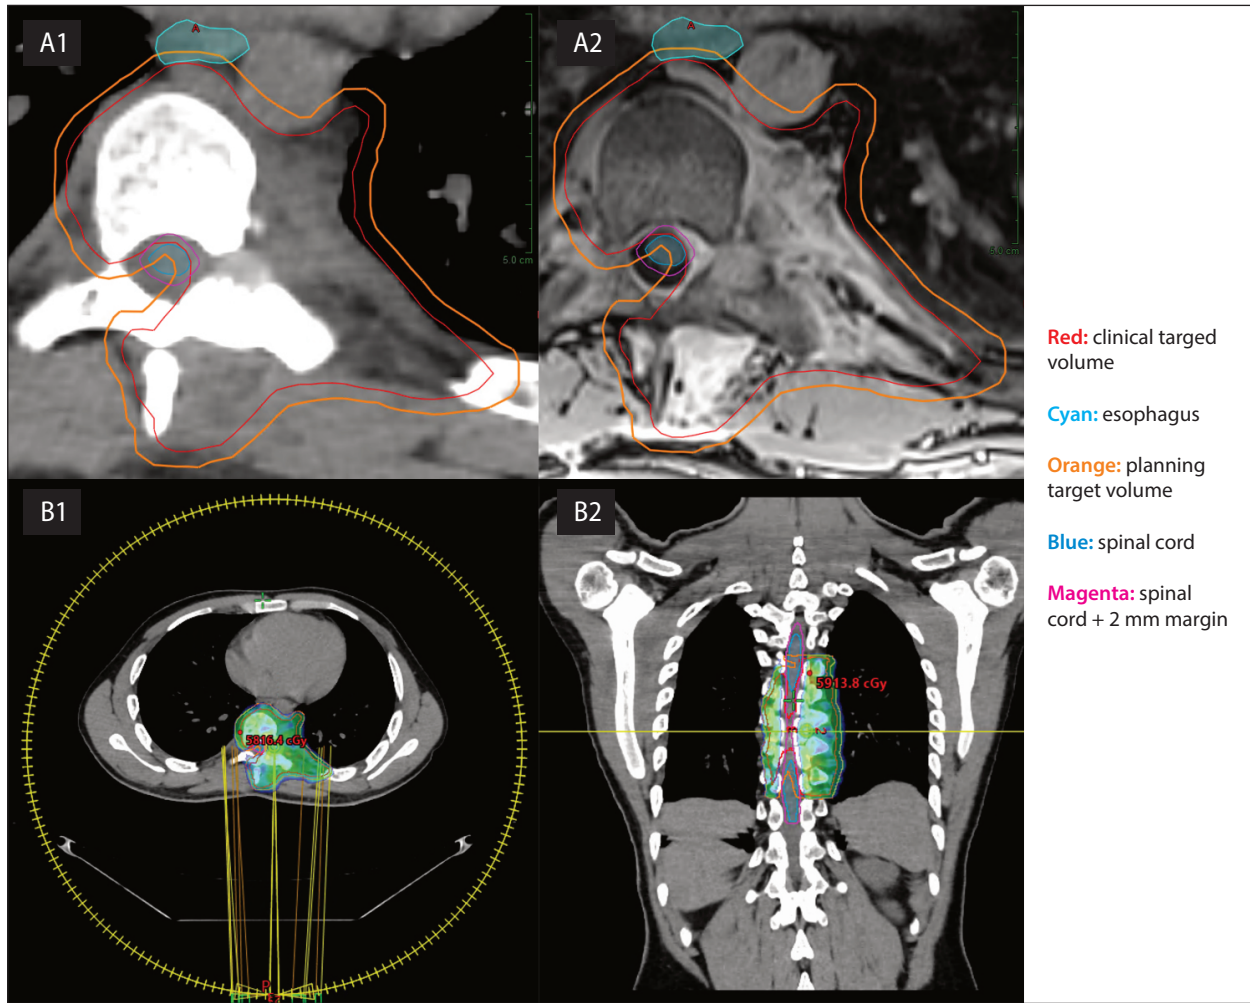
Radiotherapy planning in a patient with osteoblastoma; A. Tumor delineation based on planning computed tomography (A1) with planning magnetic resonance imaging (A2); B. Volumetric modulated arc therapy plan, the dose distribution of 56 Gy in 2 Gy fractions in transversal (B1) and coronal views (B2), 95% of the prescribed dose (53.2 Gy)
